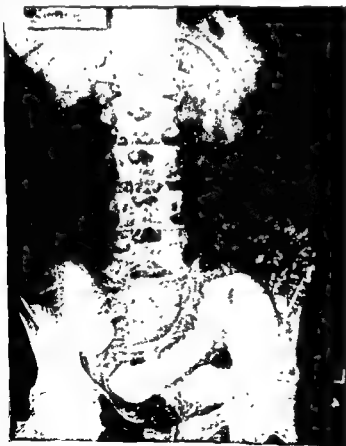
Roentgenogram of the small intestine in a case of regional enteritis, showing the "string sign" and dilated bowel proximal to the narrowed portion (in this case, below).
